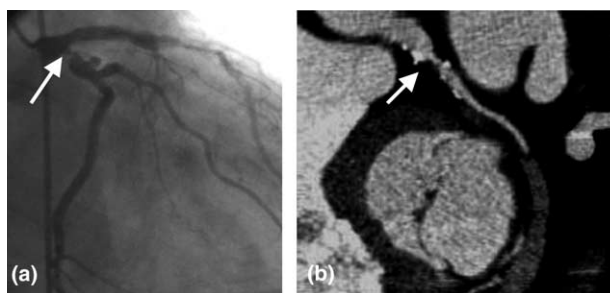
(a) Angiogram shows a significant stenosis of the proximal circumflex (RAO projection). (b) MSCT (MIP) confirms the presence of a significant stenosis of the proximal circumflex artery. MIP: maximum intensity projection; MSCT: multislice computed tomography; RAO: right anterior oblique.
